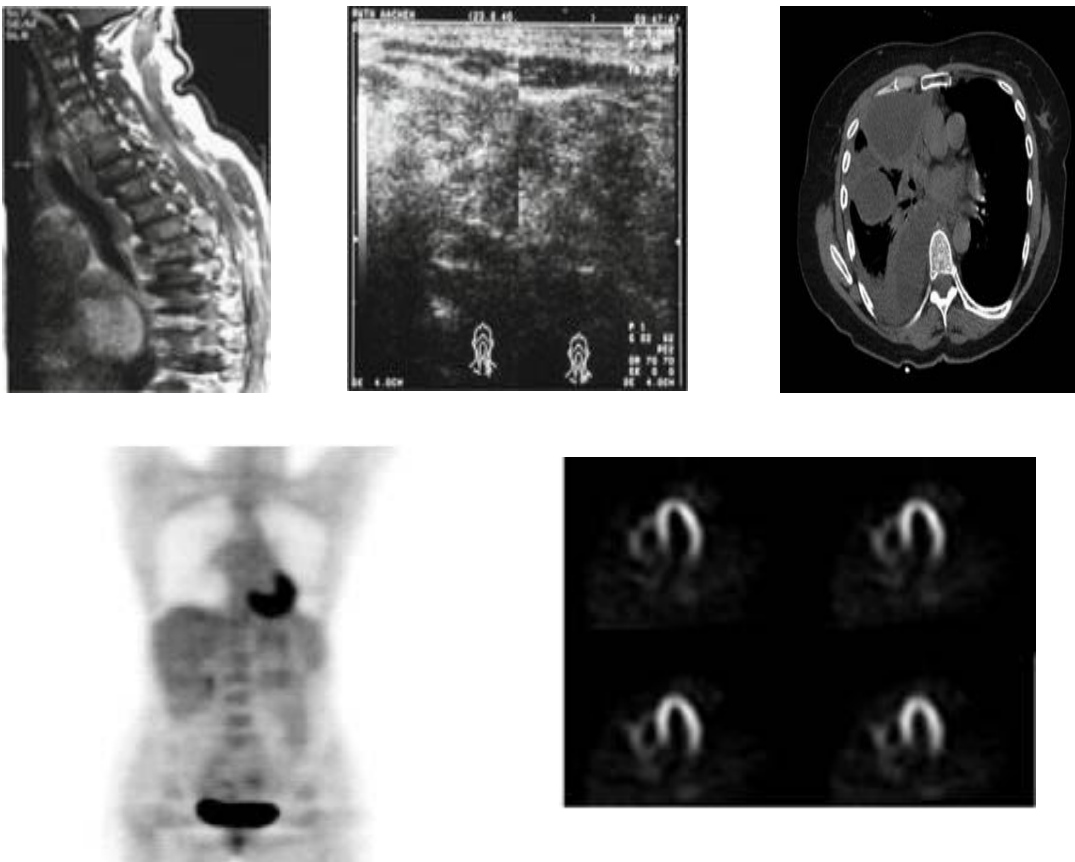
Examples of imaging methodologies routinely used in clinical practice. From left to right: (top) Magnetic Resonance Imaging (MRI), Ultrasound (US) and Computer Tomography (CT) [taken from [1](#)]; (bottom) Positron Emission Tomography (PET) (taken from [6](#))
